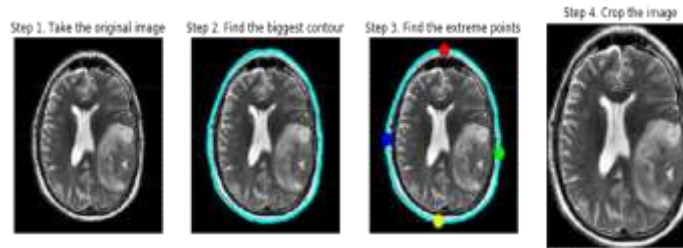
Brain MRI images sample dataset
